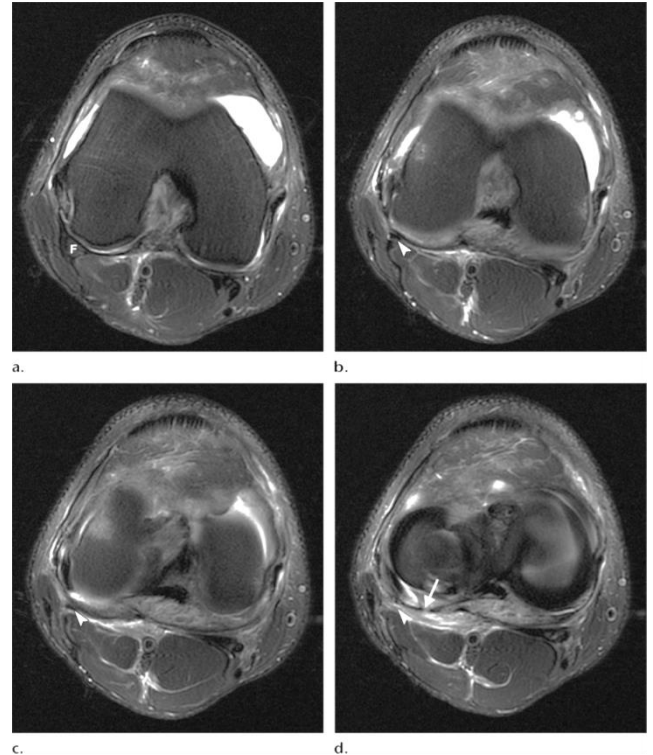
Ruptured fabellofibular ligament in a 31-year-old woman. Serial axial T2-weighted fat-suppressed MR images show the proximal fabellofibular ligament (arrowhead in band c) originating from the fabella (F). At the level of the joint line, the fabellofibular ligament is no longer visualized (arrowhead in d) where there is soft-tissue edema along the PLC of the knee and focal disruption of the arcuate ligament (arrow in d) (28).
